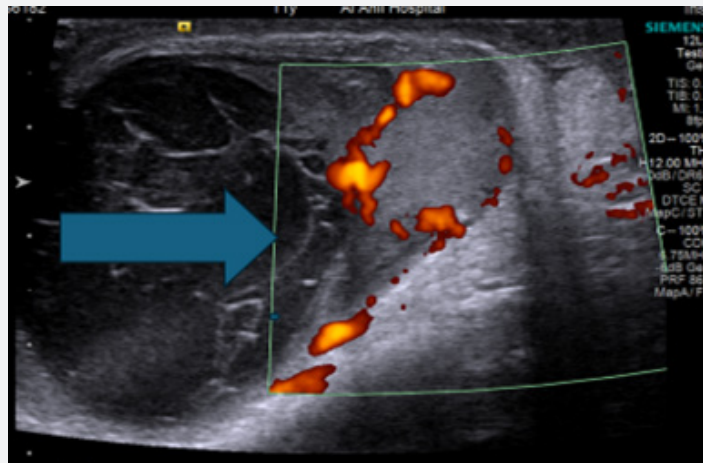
U/S Doppler significantly increased vascularity of the testis.
